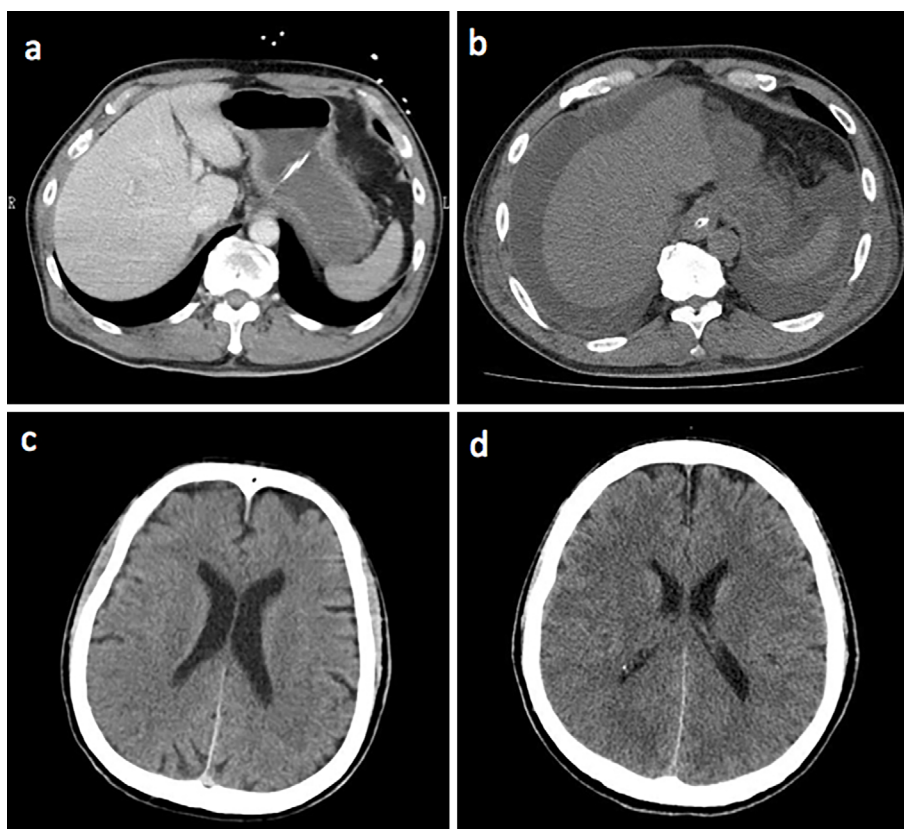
CT scans for the abdomen (a, b) and the brain (c, d) obtained on Day 4 and Day 7 from the onset, respectively. Liver atrophy with ascites was observed during the course. Brain edema was noted on Day 7.
